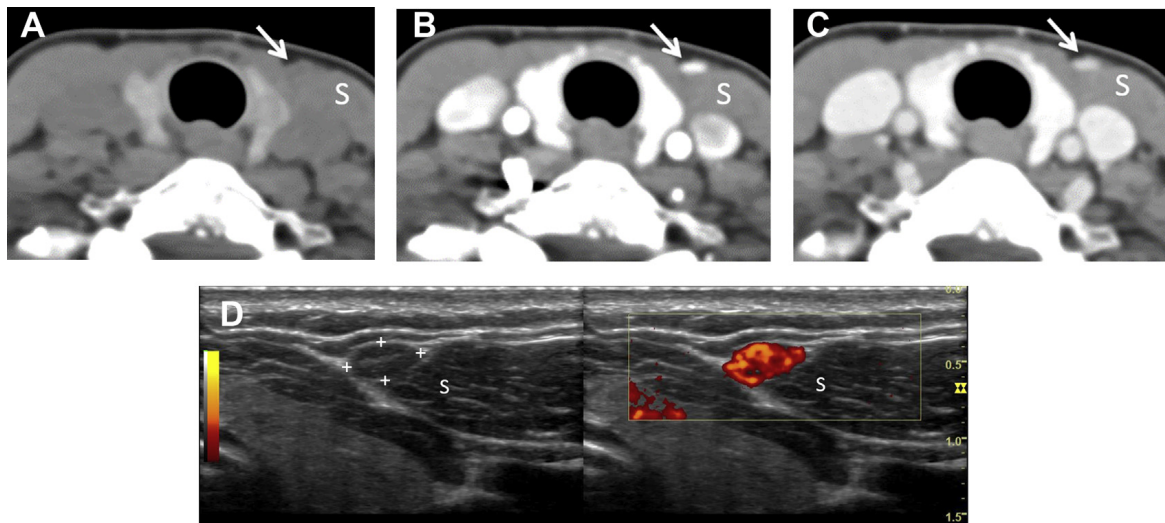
Reimplanted parathyroid. A 56-year-old woman status post parathyroidectomy with reimplantation of one gland presents with recurrent hyperparathyroidism. (A–C) 4DCT images demonstrate a small nodule (*arrows*) anterior to the sternocleidomastoid muscle (S) that enhances avidly in the (B) arterial phase and washes out in the (C) venous phase, typical of a parathyroid adenoma. (D) Preoperative ultrasound was performed for marking the reimplanted gland, and demonstrates an enlarged parathyroid gland (*cursors*) superficial to the most medial aspect of the left sternocleidomastoid muscle (S) with intense hypervascularity.
